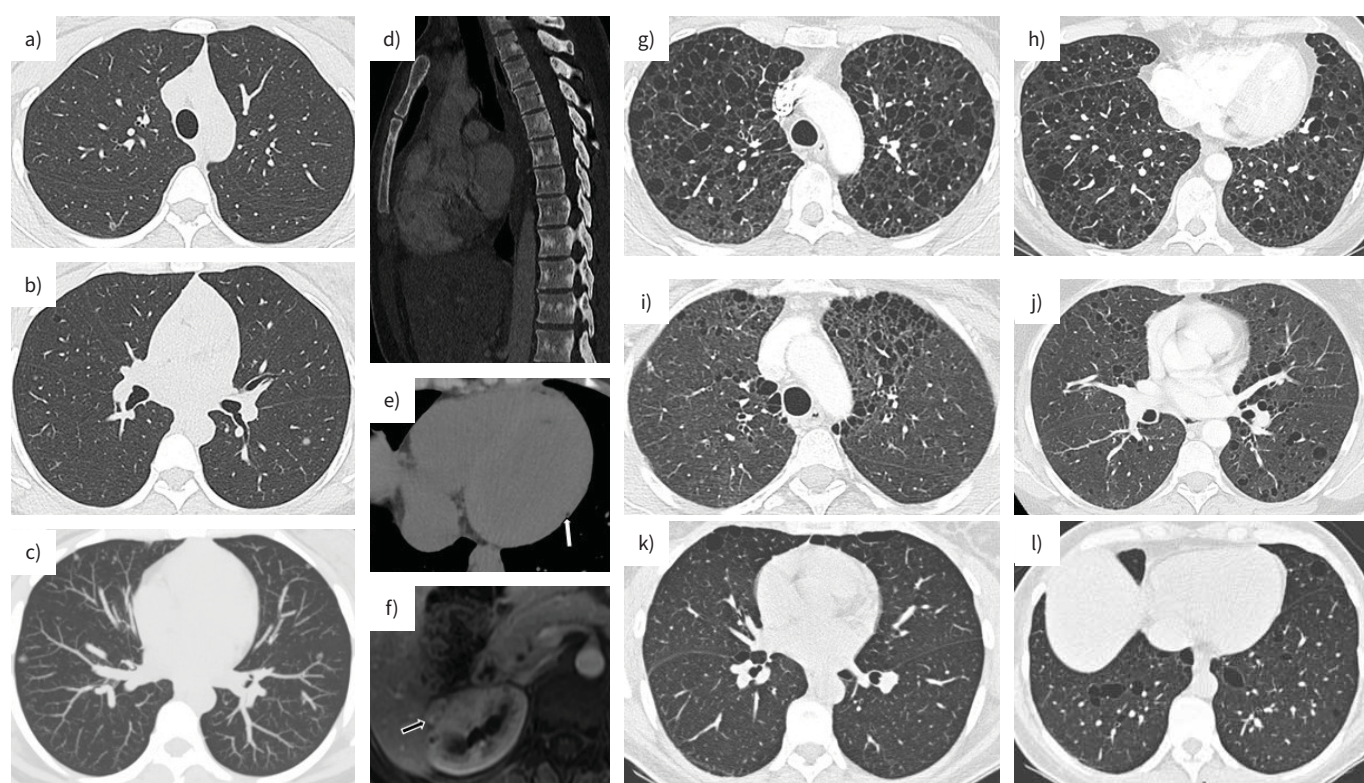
Computed tomography (CT) patterns of cystic lung disease of genetic origin. a, b and c) 31-year-old woman with confirmed tuberous sclerosis complex. CT shows multiple bilateral solid and nonsolid small lung nodules (displayed with maximum intensity projection, c) suggesting multifocal micronodular pneumocyte hyperplasia, associated with a few small lung cysts and multiple sclerotic lesions of the thoracic and lumbar vertebrae (sagittal view, d). A few fatty foci are visible in the myocardium on the unenhanced chest CT (white arrow, e) and the magnetic resonance imaging shows an enhancing right renal nodule related to a lipid-poor angiomyolipoma (black arrow, f). g and h) 48-year-old woman with tuberous sclerosis complex–lymphangioleiomyomatosis with characteristic bilateral, round, well-defined, uniform, thin-walled cysts with diffuse distribution. i and j) 46-year-old smoking woman with known neurofibromatosis type 1 disease and numerous upper-lobe-predominant lung cysts that remained stable over 7 years of follow-up; however, she developed pulmonary hypertension that led to lung transplantation and death. k and l) 49-year-old woman with asymptomatic cystic lung disease revealing Birt-Hogg-Dubé syndrome. The cysts are characteristically lenticular in shape, located along the pleura and bronchovascular bundles, with a predominantly basal distribution.
